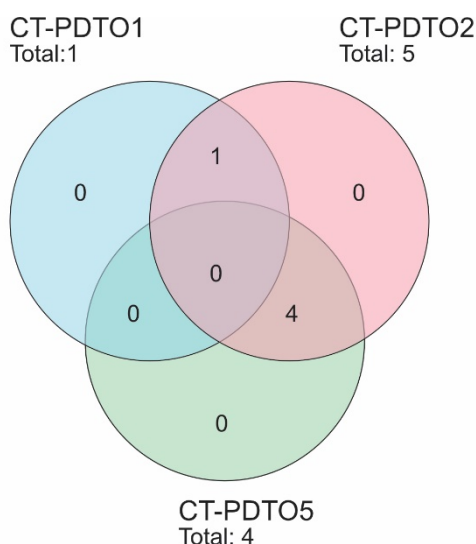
Upregulated Hallmark gene sets in CT-PDTO lines
